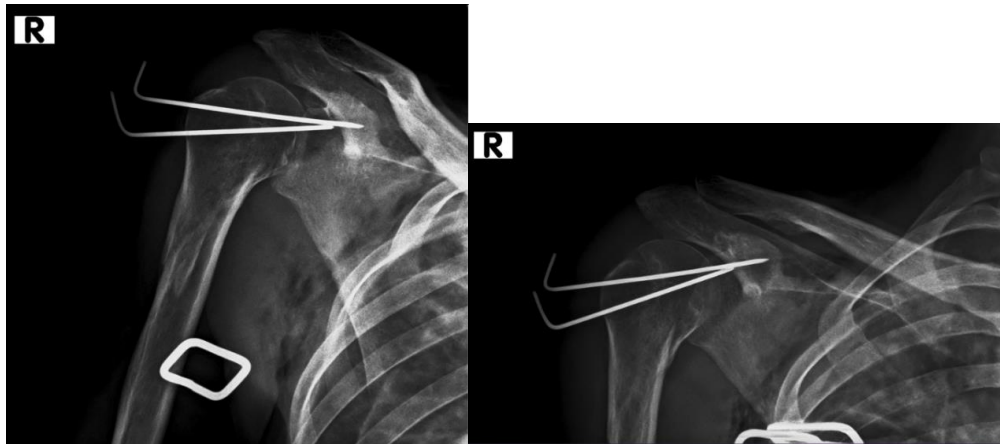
Post-operative X-ray antero-posterior view of the right shoulder showing a reduce glenohumeral joint with fixation of two Kirschner wire.
